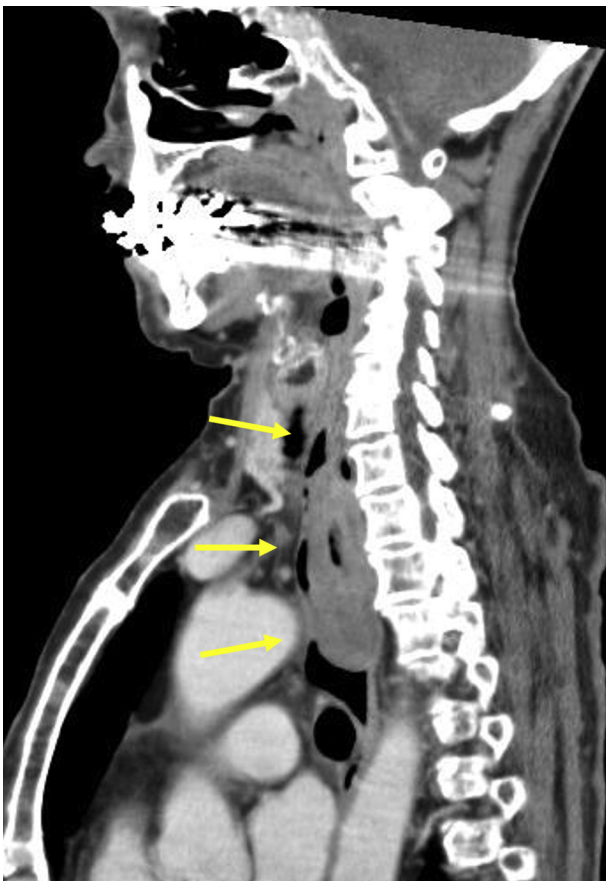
Sagittal CT showing the fibrovascular polyp arising from the proximal esophagus (arrow).
